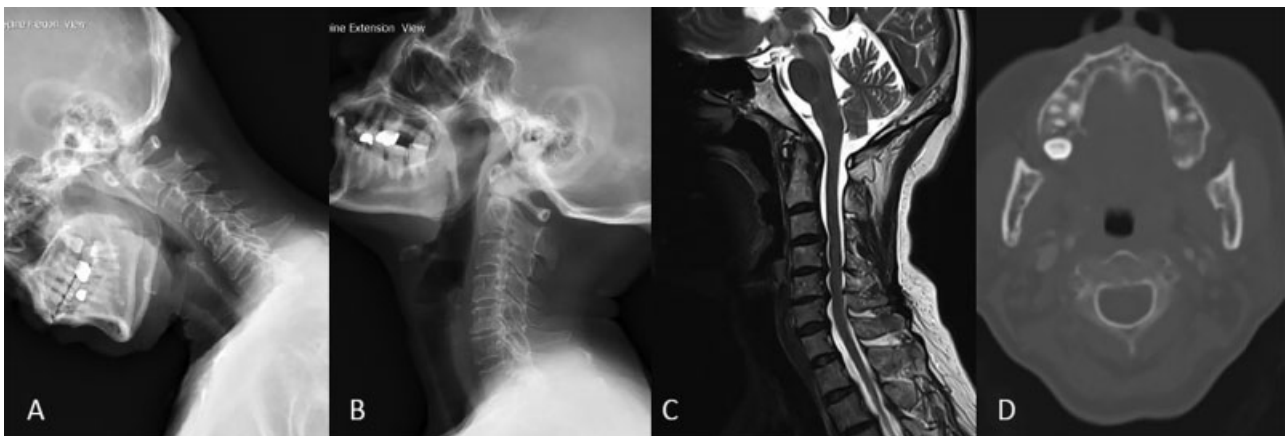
Image of third case, C1–2 subluxation. (A) Flexion view. (B) Extension view. (C) MRI T2 sagittal view, no spinal stenosis at C1–2 level. (D) CT axial view at C2 level. Both pedicles are more than 3.5 mm. CT, computed tomography; MRI, magnetic resonance imaging.
